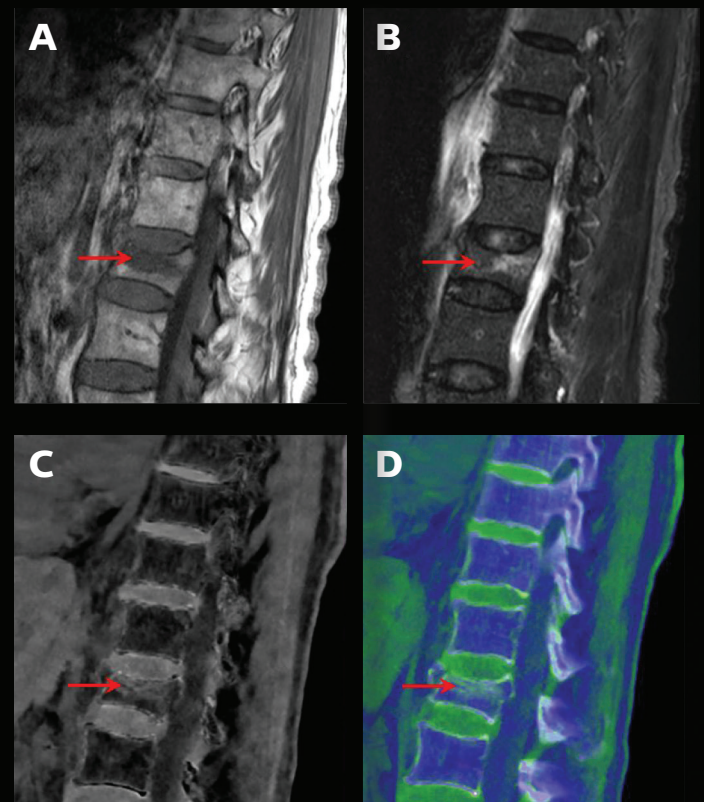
Figure B Sagittal (STIR) MRI image shows L1 bone marrow edema (arrow).
